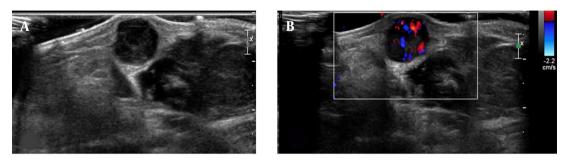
Transverse ultrasonography (A), and color Doppler (B), images show a hypoechoic solid mass in the subcutaneous fat layer with intralesional hypervascularity.
